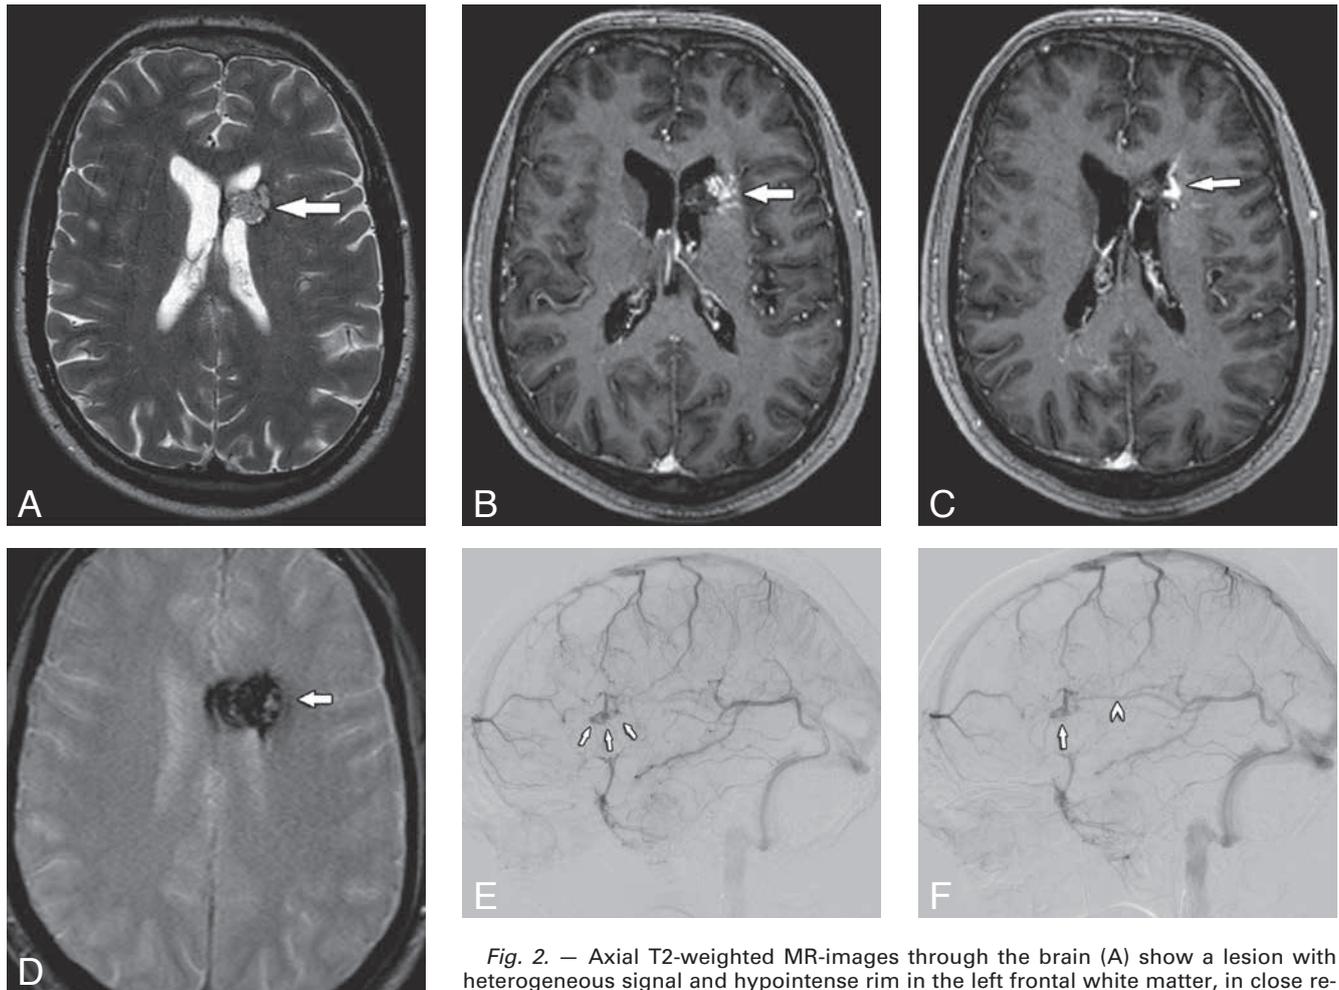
Axial T2-weighted MR-images through the brain (A) show a lesion with heterogeneous signal and hypointense rim in the left frontal white matter, in close relationship with the frontal horn of the left lateral ventricle, representing a cavernous malformation. Axial T1-weighted images post gadolinium obtained at the same level
